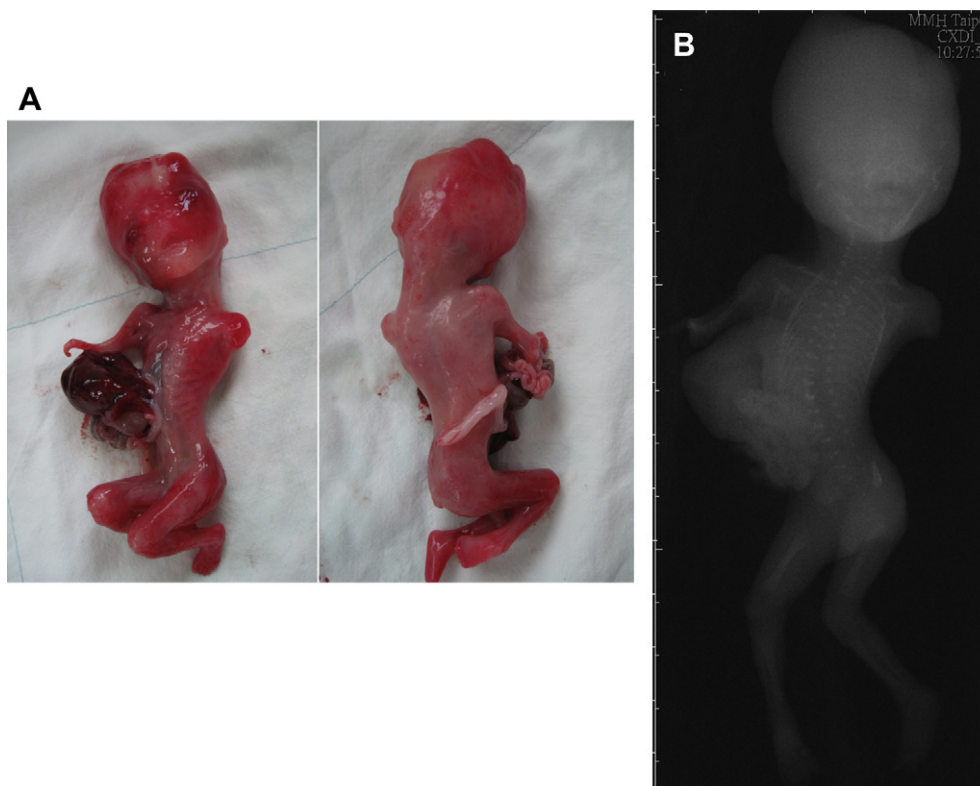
(A) Anterior view and posterior view of the fetus at birth at 14 weeks of gestation. (B) Corresponding X-ray image of the fetus.
